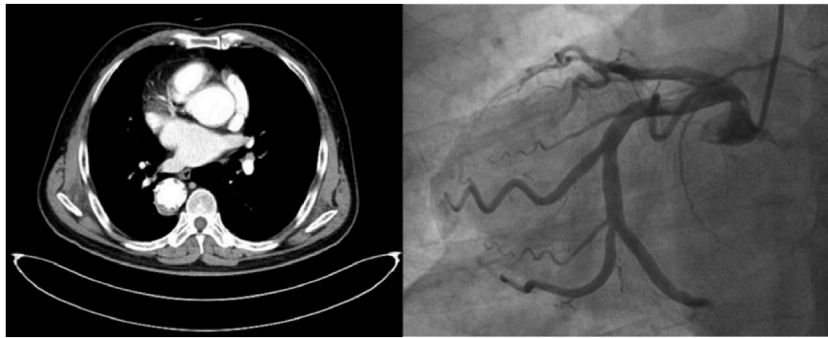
(A) Multidetector computed tomography angiography revealed an ascending aortic aneurysm. (B) Coronary angiography showed that blood perfusion was quite slow in the left coronary artery but with no evidence of significant atherosclerosis (supplementary files can see this process obviously).
